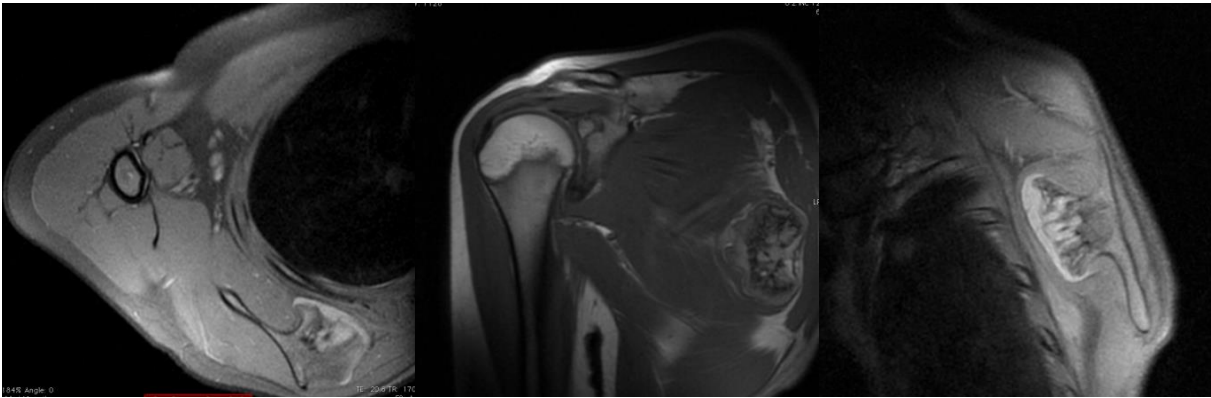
MRI sections revealing an inhomogenous tumor, on the medial side of scapula, adjacent to the inferior angle, that impinges the nearby muscular structures.
